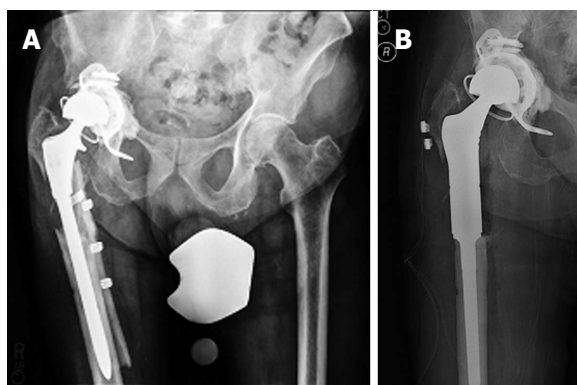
Proximal femur replacement using the so-called “mega-prostheses” is an alternative option in cases of severe proximal femoral bone loss. A: Anteroposterior (AP) radiograph of the pelvis showing a left revision total hip arthroplasty in a 82-year-old male patient with an extensive structural defect of the lateral femoral cortex resulting in a painful and mechanically loose construct of a periprosthetic hip fracture; B: Postoperative AP radiograph of the right hip showing the replacement of the proximal femur with a megaprosthesis.
